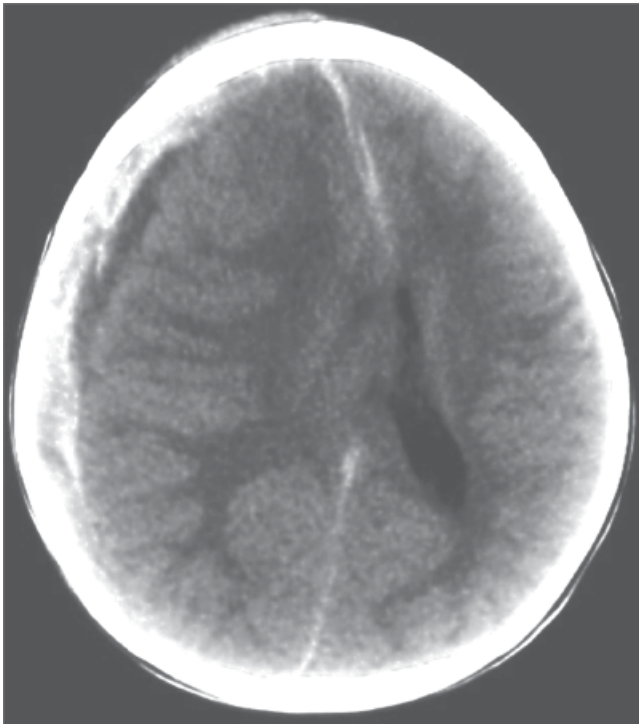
Non-contrast axial CT in a 2-year-old comatose boy shows a large right acute subdural hematoma. It is important to notice the tremendous shift of the midline to the left.
